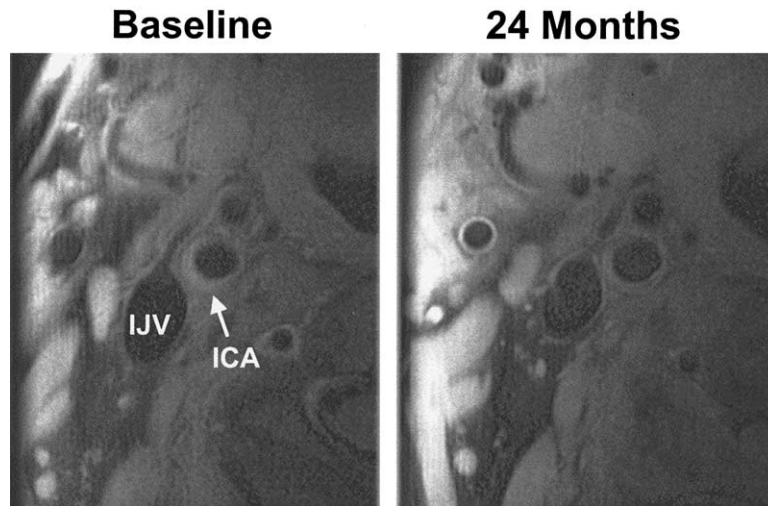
Representative cross-sectional magnetic resonance image of the same patient at baseline and at 24 months of statin treatment showing plaque regression at the level of the right carotid artery bifurcation. ICA = internal carotid artery; IJV = internal jugular vein.
